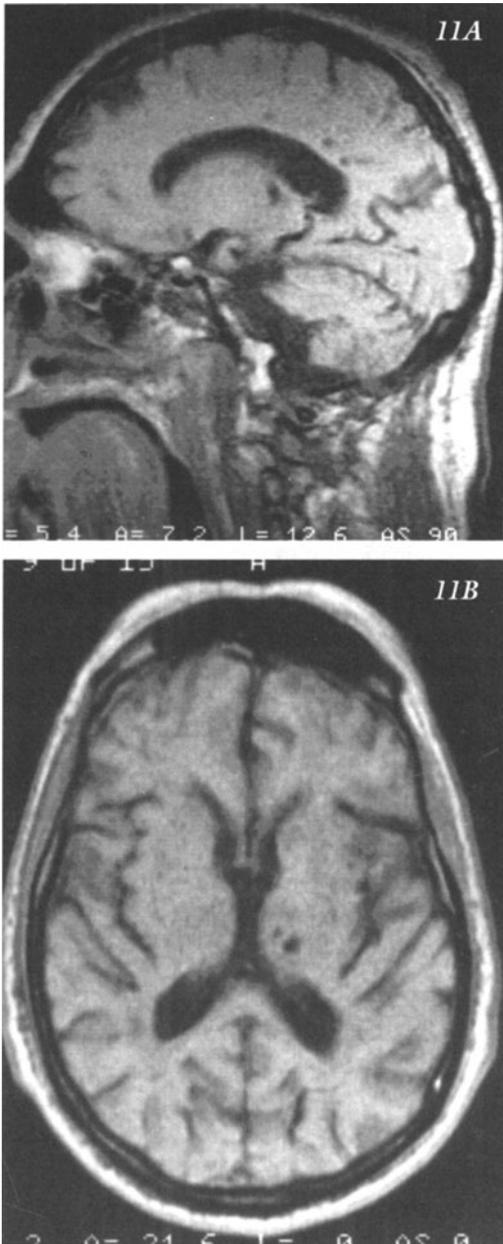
Multiple lacunar infarcts most prominent in penetrating branches left posterior cerebral artery: thalamus, posterior one third corpus callosum and adjacent white matter of left posterior cerebral hemisphere in a 70 year old right handed hypertensive male with multiple episodes of “collapse”, possibly related to severe orthostatic changes. A) MRI - T1 weighted sagittal section- 12.6 mm left of midline) MRI-horizonal section.
